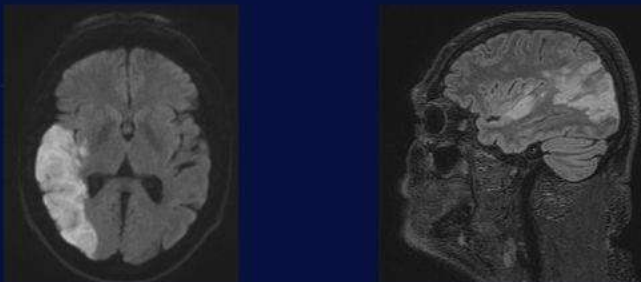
Post-warfarin loading MRI Brain
